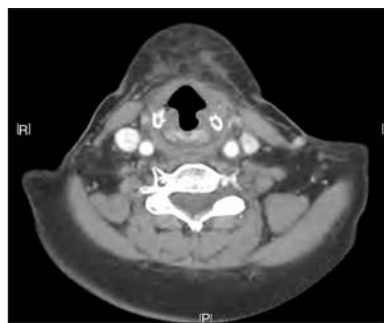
Computed tomography taken 4 months after conclusion of the protocol for concurrent radiation therapy and chemotherapy.
